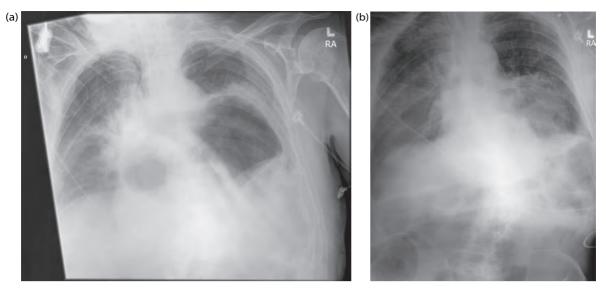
(a) Chest radiograph depicting large diaphragm rupture with herniation of the stomach into the left chest before stomach decompression. (b) Same patient as in (a), after placement of a nasogastric tube.
